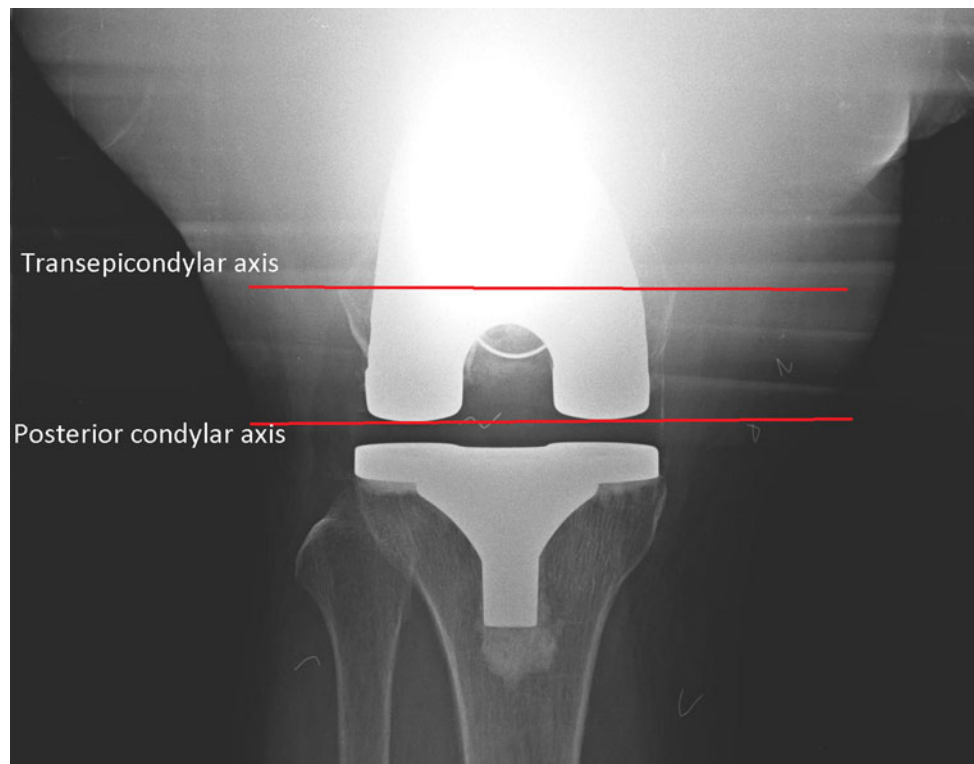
Axial radiograph showing the transepicondylar axis and posterior condylar axis. The two femoral rotation axes should be parallel and measuring the angle between two *orthogonal lines* was drawn
